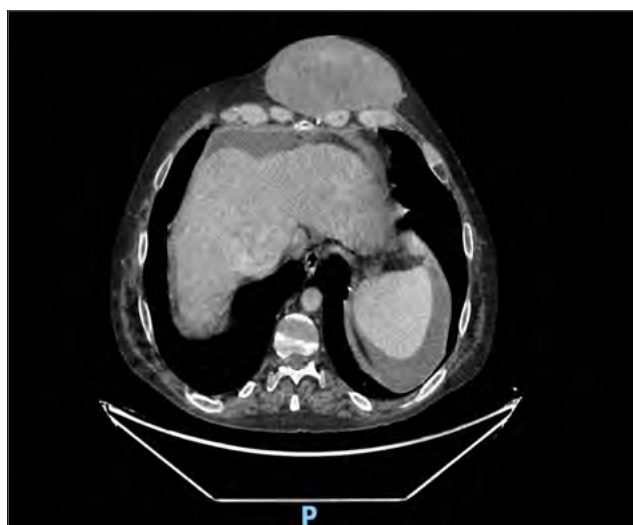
Pre-operative transversal CT scan showing the huge mass in close contact with sternum and ribs.
